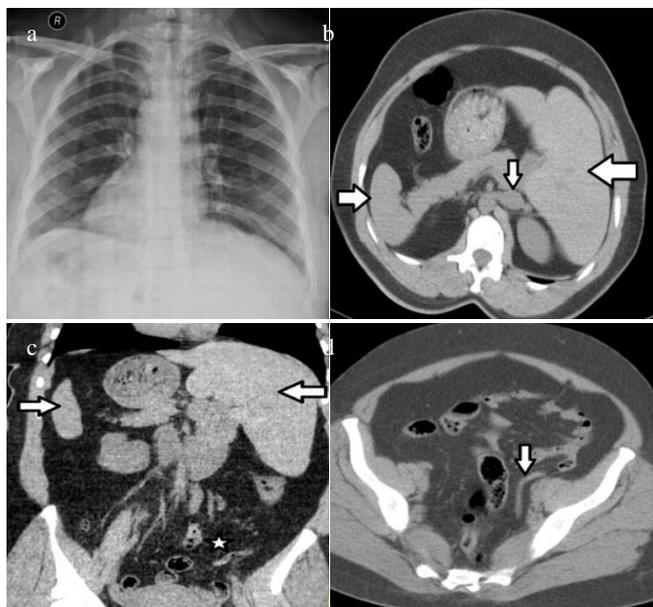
a: Dextrocardia in PA lung x-ray, b: Liver located on the left (right arrow), VCI located on the left (downward arrow), spleen (left arrow) located on the right, c: Liver located on the left (right arrow) and spleen located on the right (left arrow), inflamed appendix (star) in the lower left quadrant, d: Blind-ending of the inflamed appendix on the left lower quadrant
